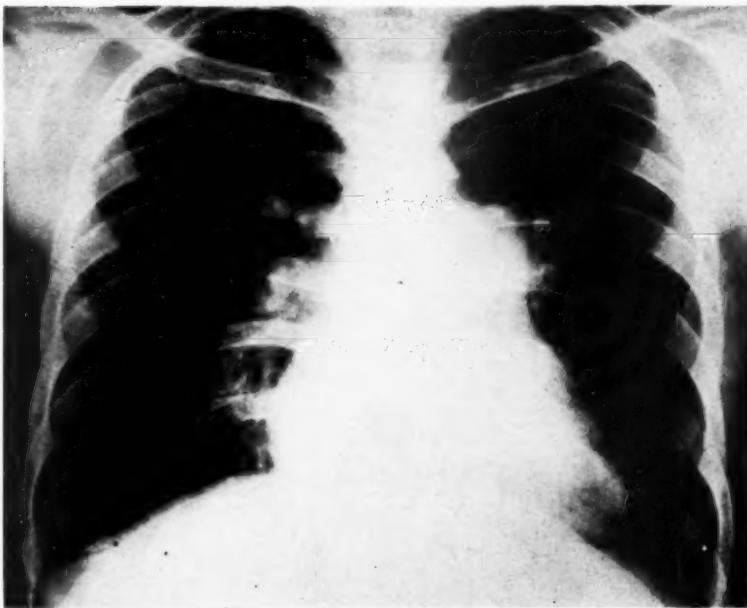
Roentgenogram of chest of Patient 2. This shows the characteristic pulmonary conus enlargement and accentuated right hilar shadow.
